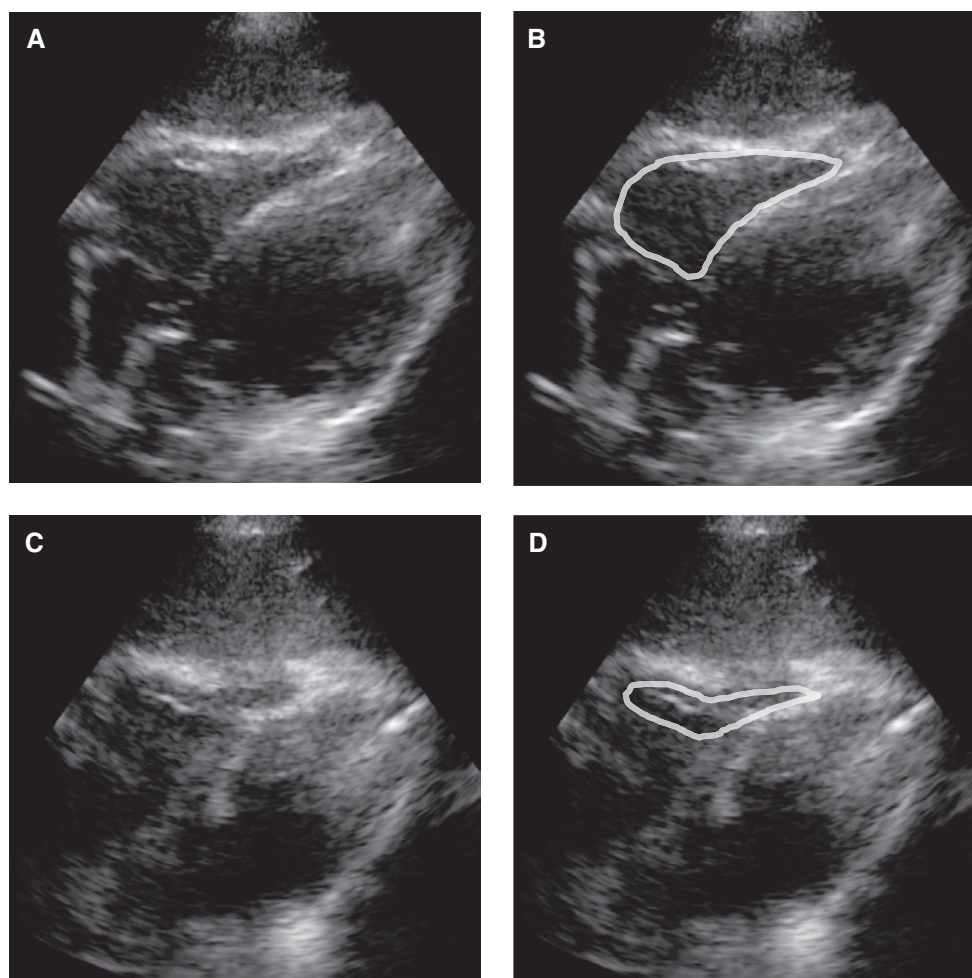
Subxiphoid cardiac imaging by an experienced sonographer (Subject 1). A) Subxiphoid imaging at rest before profile initiation. B) The same image is presented with a white outline of right ventricle volume. C) Subxiphoid imaging while relaxed at +3.5 G_z . D) The same image is presented with a white outline of right ventricle volume. Note the relative collapse of the right ventricle and the partial loss of the ideal cardiac imaging window due to challenging probe management under hypergravity conditions.
